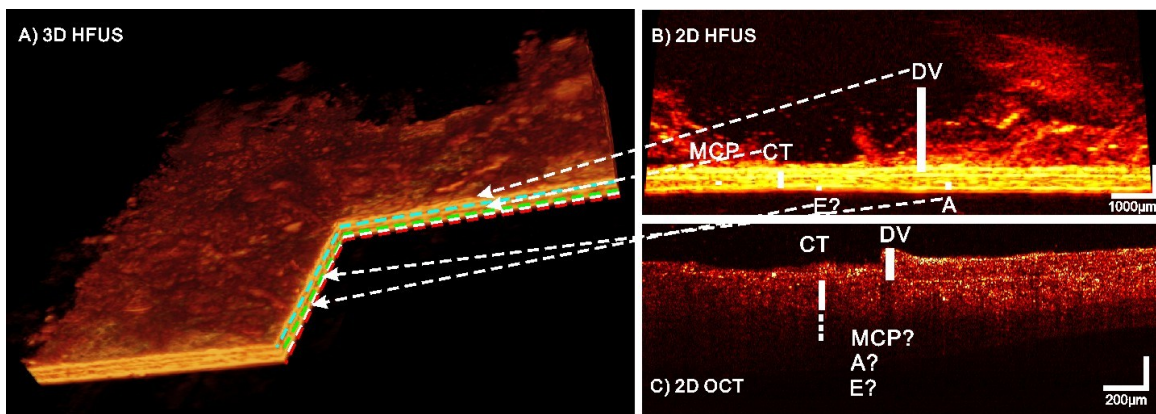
3D HFUS image of a human FM with thick MCP. A): 3D HFUS image; B): a slice of 2D HFUS from image A); C) corresponding 2D OCT image. Despite the lower spatial resolution, HFUS was able to penetrate the entirety of the thicker FMs while the image depth of OCT was limited to layer DV or top CT.
